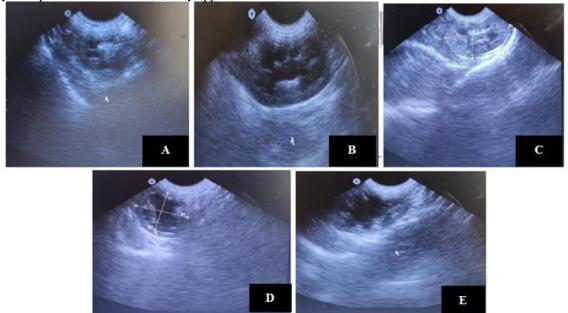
ultrasonography for kidney after induction of partial bilateral ureteral ligation (group B) (A)Normal kidney before induction of bilateral ureteral ligation. (B) kidney 7 days post ligation, slight increase in renal pelvis size . (C) kidney 14 days post ligation, (D) kidney 21 days post ligation, renal pelvis is anechoic and increasing in size was more prominent (E) 28 days post operation, hydrronephrosis became clear , renal parenchyma was degenerated and renal pelvis has consumed the most of the kidney.
